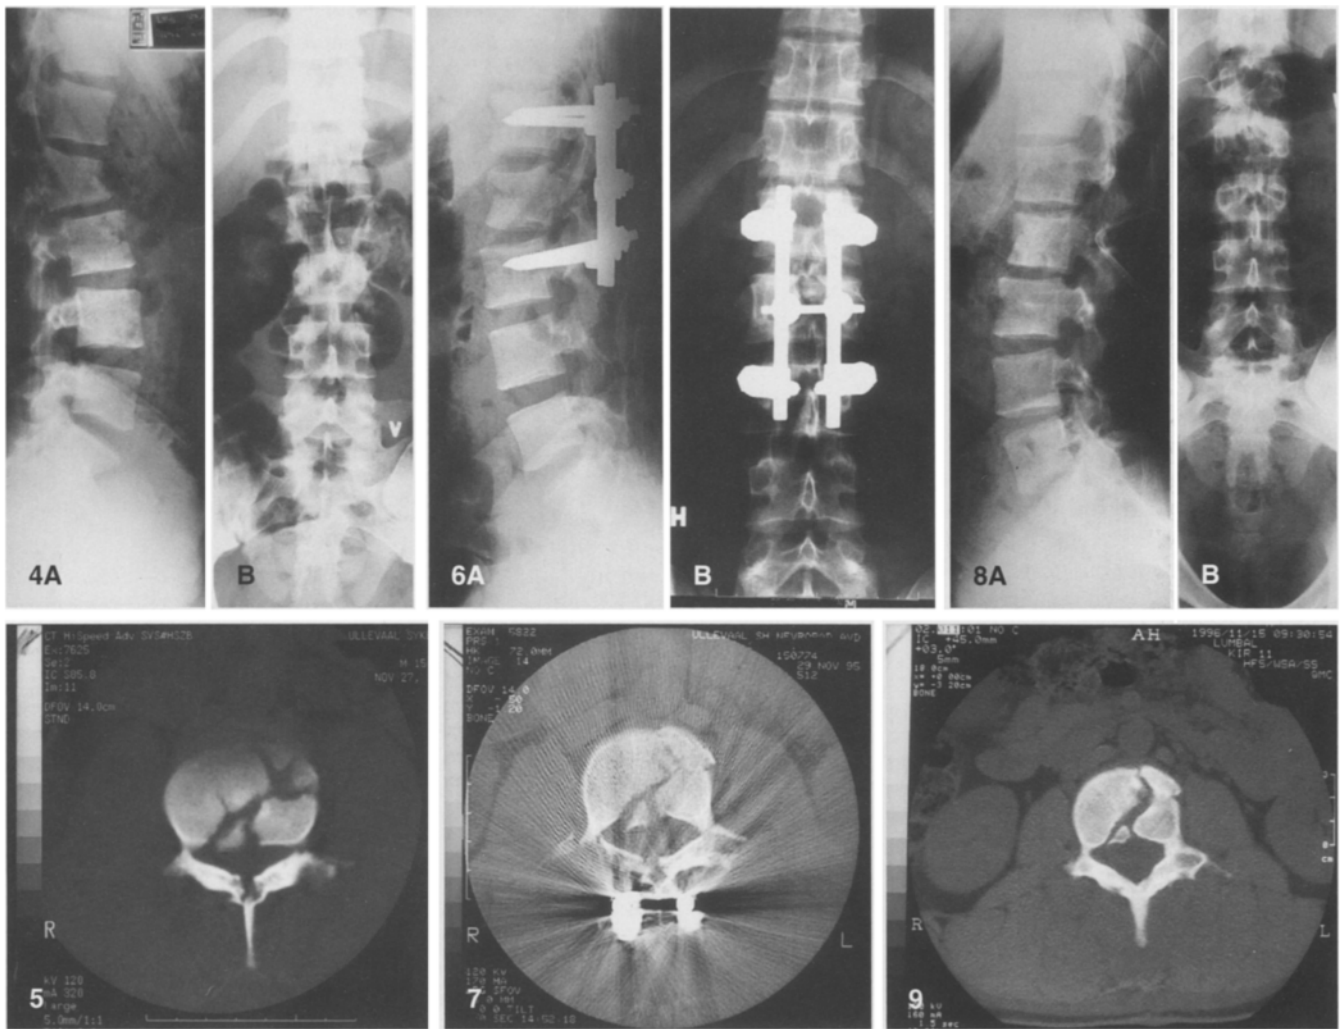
Preoperative plain radiograph of an unstable fracture in L2 in a 20-year-old man who suffered a climbing accident. There was no neurological deficiency
